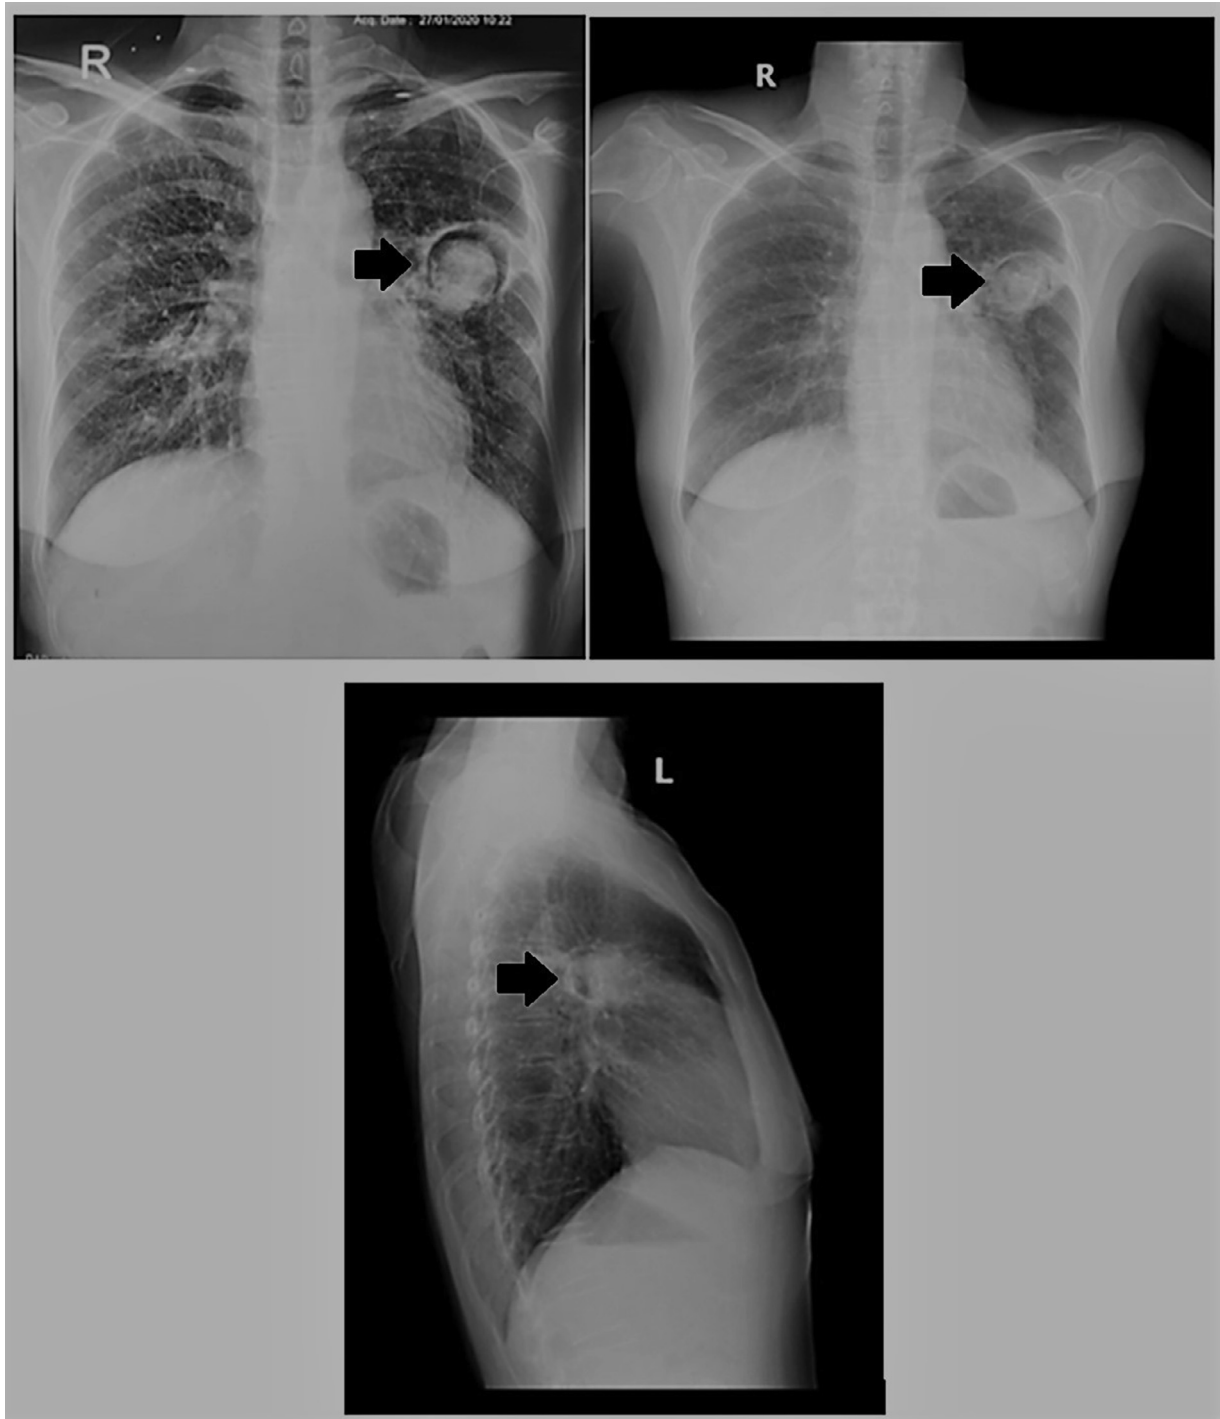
Chest x-ray showed air surrounding the fungal ball in a pulmonary cavity as pointed by arrow.
